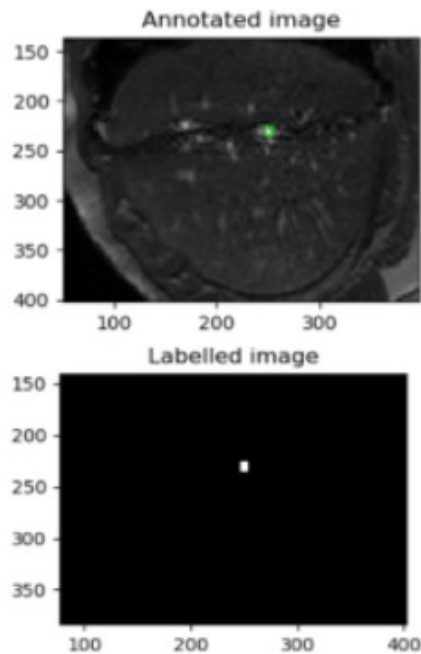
Vessel segmentation method. Upper: 2D MRI liver image rescaled and highlighted in the location of a vessel. Lower: Mask image or label corresponding to the upper image. In this case the pixel belonging to the vessel have value of 1 while the pixels of background get a value of 0. A set of those images has been fed to the automated segmentation algorithm.
